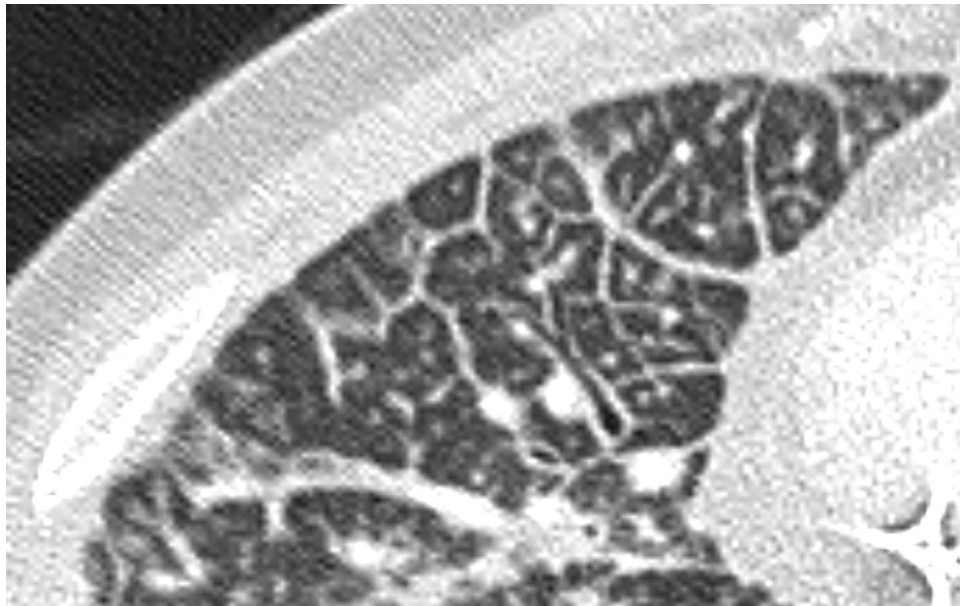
Contrast enhanced computed tomography scan of the chest better demonstrates thickened and nodular interlobular septa in the right middle lobe.
